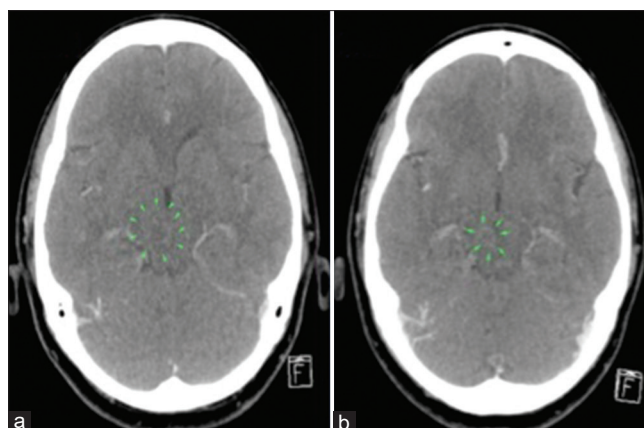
Axial contrasted CT brain image done during early admission showing faint rim enhancing midbrain lesion (a). Following 1-month treatment, repeated axial-contrasted CT brain image showing significant size reduction (b)
